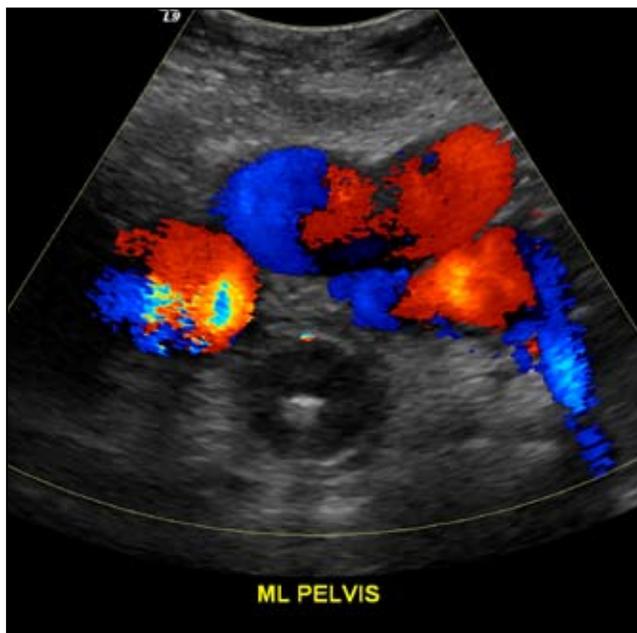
Midline transverse ultrasound over the bladder demonstrates dilated pelvic varices anterior to the bladder containing a Foley catheter.
